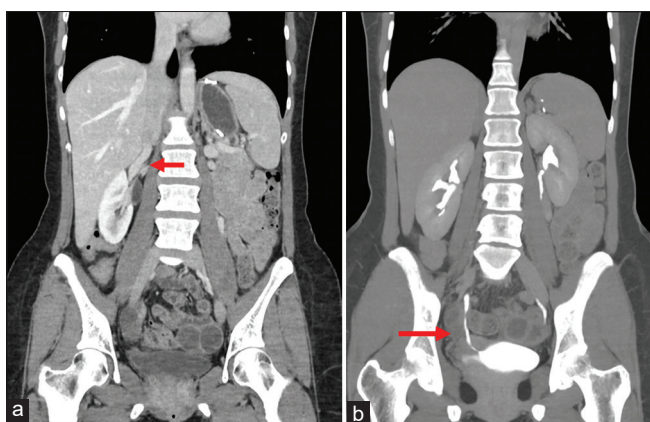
(a) Follow up CT urography showed complete resolution of bilateral renal & gonadal veins thromboses (arrow at the right renal vein) and (b) patent right urinary system (arrow at anastomosis site)
